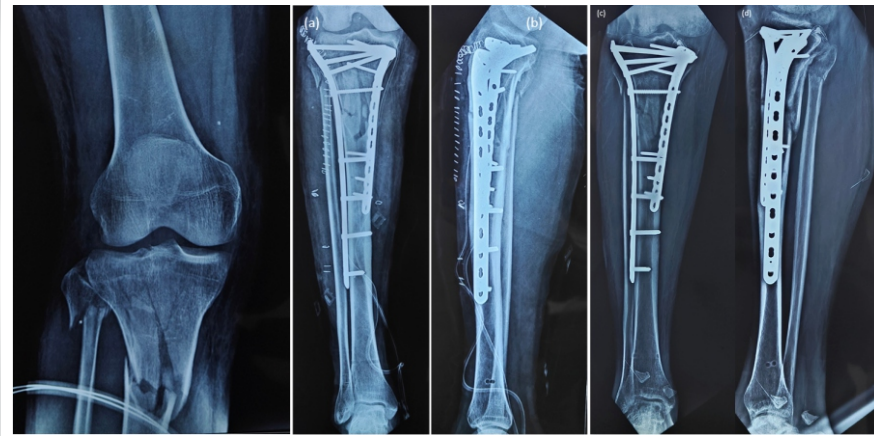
Case 2 Proximal tibia fracture anteroposterior radiograph, post operative day 1 (a, b), post operative 3 months (c, d)
